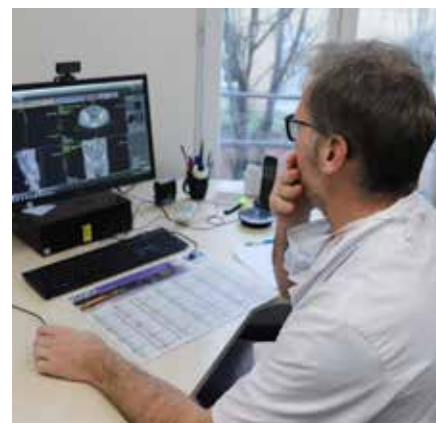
CT angiogram analysis and fusion preparation directly in the office thanks to the AW Server..
